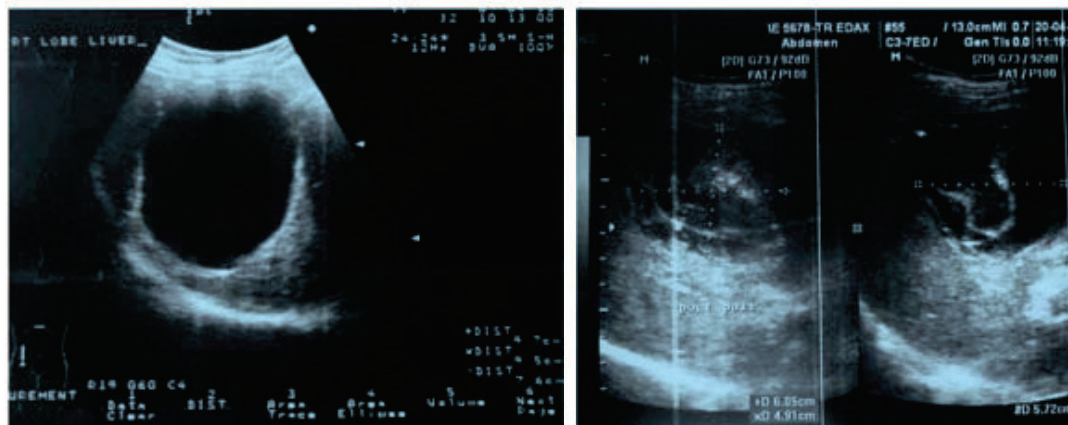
Ultrasonographic images showing Pre (08/01/2009) & post PAIR (4 months, 01/05/2009) hepatic hydatid cyst
